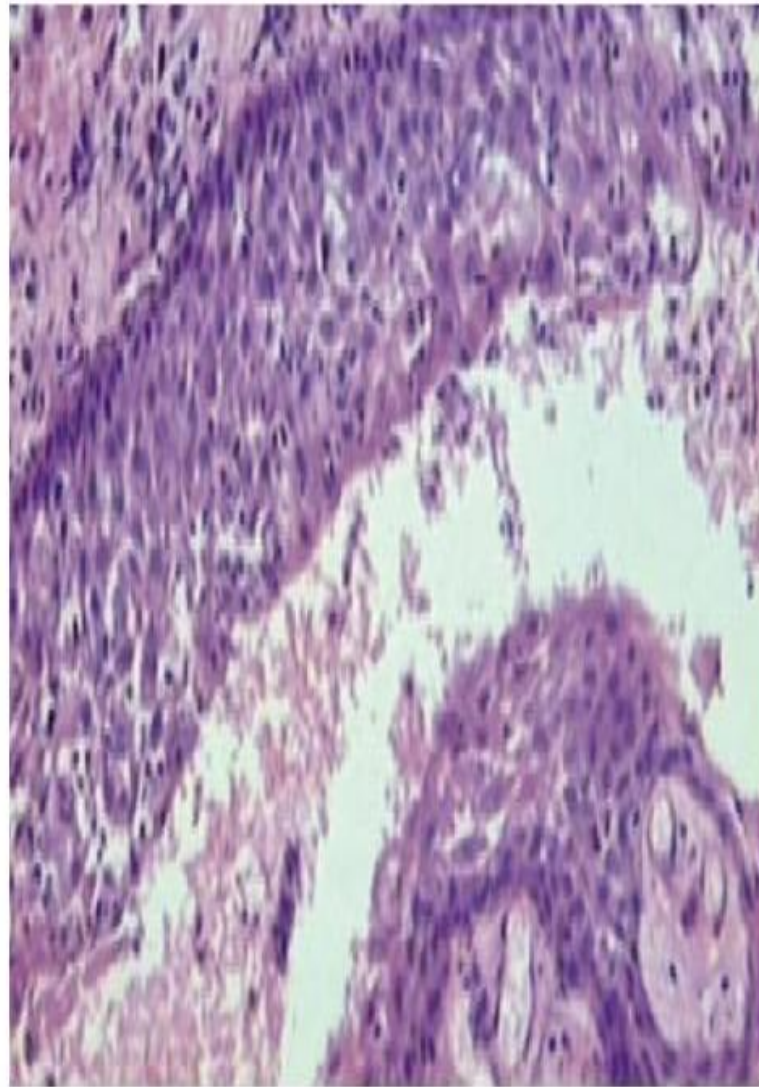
Periapical cyst
